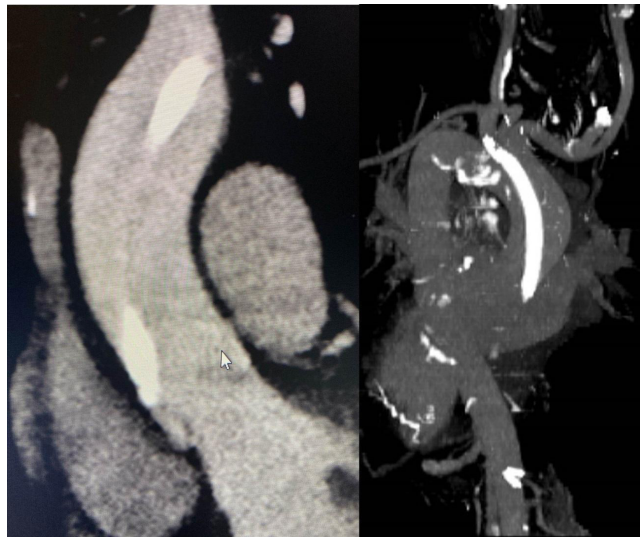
CTA Chest: A temporary hemodialysis catheter appears to enter at the confluence of the internal jugular and left subclavian vein. It then traverses through the hemiazygos vein and subsequently enters the aorta at the junction of the right brachiocephalic artery. The catheter terminates just above the aortic valve.
